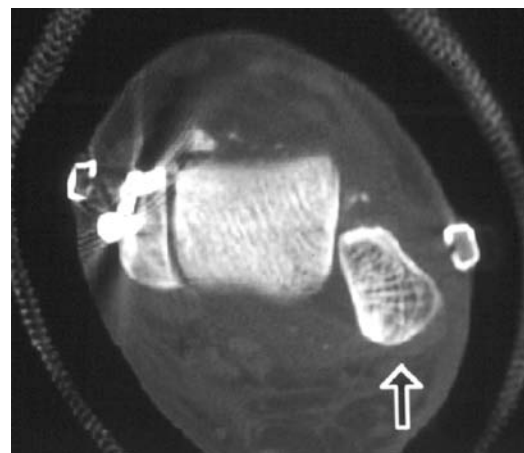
CT scan of another patient with a malreduced syndesmosis.
